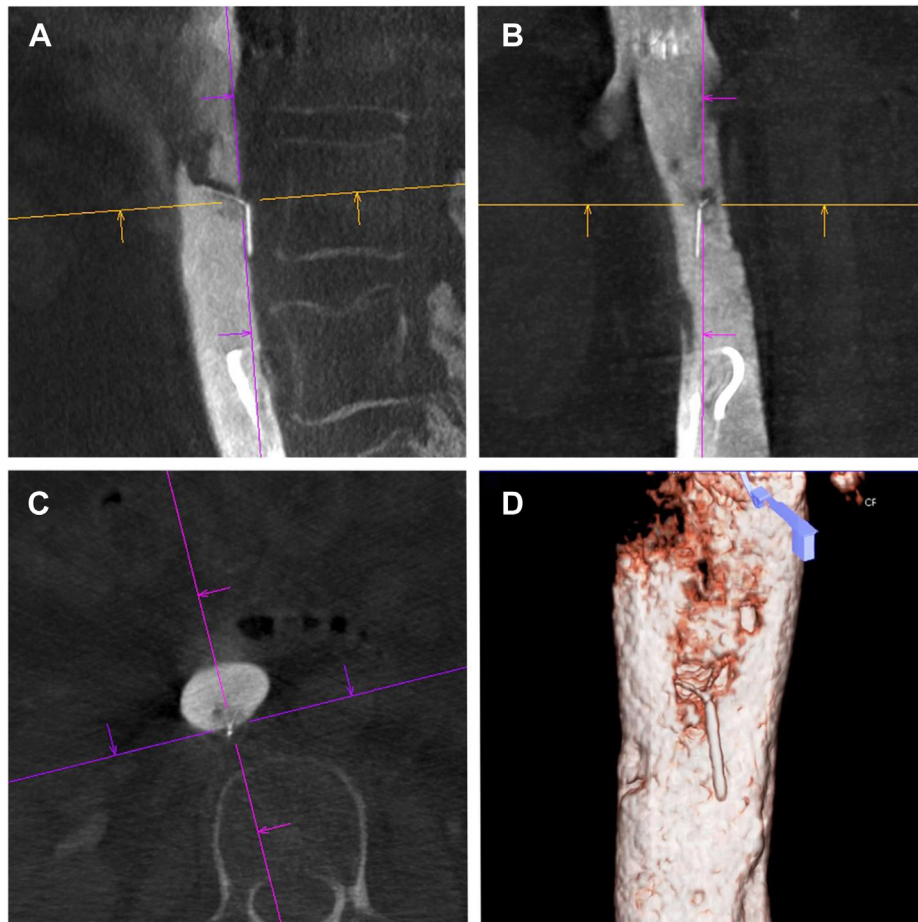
Determining the position and orientation of the fractured strut with intraoperative cone-beam computed tomography (CBCT). Intraoperative CBCT scans showing fractured strut penetrating the inferior vena cava (IVC) and associated thrombus: sagittal view (A), coronal view (B), and axial view (C). D, Three-dimensional rendered image of the fractured strut.
